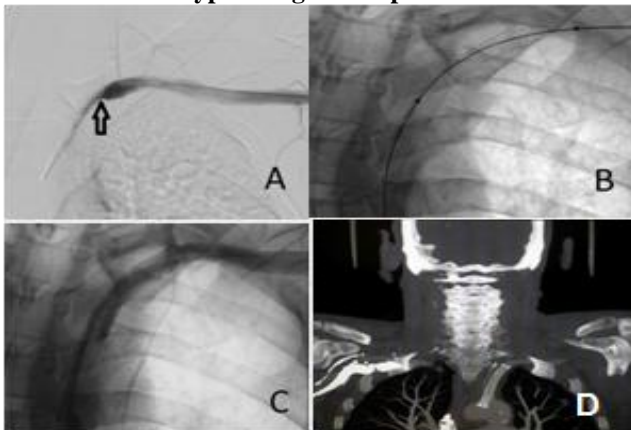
A, B, C endovascular procedure showing angioplasty and placement of a right subclavian artery stent. D: CT control.
